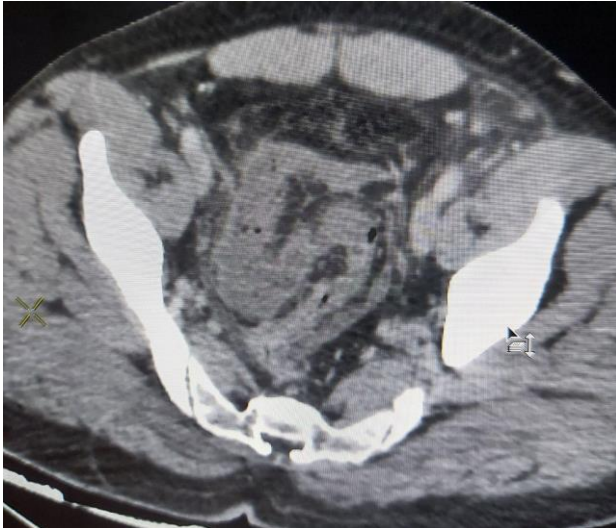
CT-Scan showing sigmoid necrosis
